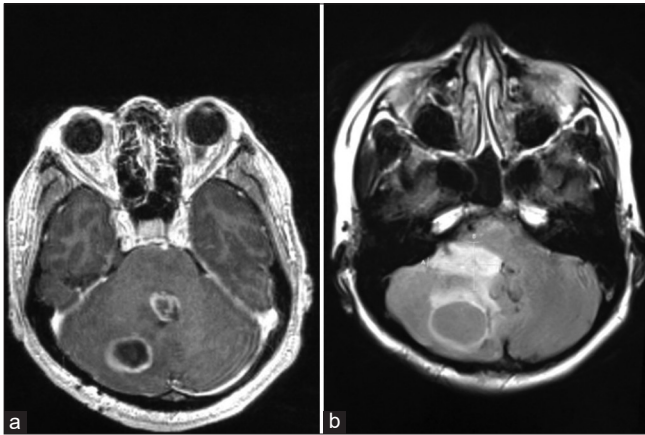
Eleven months after the first surgery, the patient presented with tumor recurrence. (a) Two lesions, one in the right cerebellar hemisphere, which is consistent with the location of the original tumor. Another lesion is seen centered in the fourth ventricle, likely arising from the residual tumor infiltrating the ventricular wall; (b) axial flair magnetic resonance imaging shows a portion of the tumor arising from the right lateral aspect of the fourth ventricular wall.
